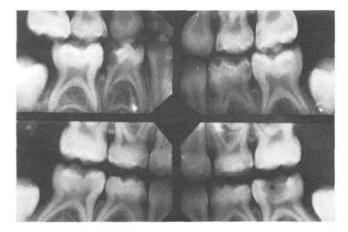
Radiographs from two children excluded from the study because they did not fit the criteria.
